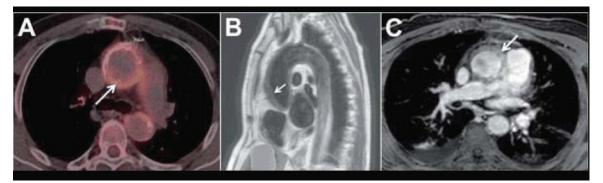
(A) Positron emission tomography-computed tomography scan 3 years prior to admission showing hypermetabolic thickening of the ascending aorta (*arrow*), with a standardized uptake value of 5.9. The ascending aorta is dilated, with a maximal diameter of 41 mm, consistent with inflammation. (B and C) Magnetic resonance, T1-weighted high-resolution isotropic volume examination, and T1-weighted images, respectively, on day 2 after admission, showing thickening (13 mm) of the wall of the ascending aorta (*arrows*).
